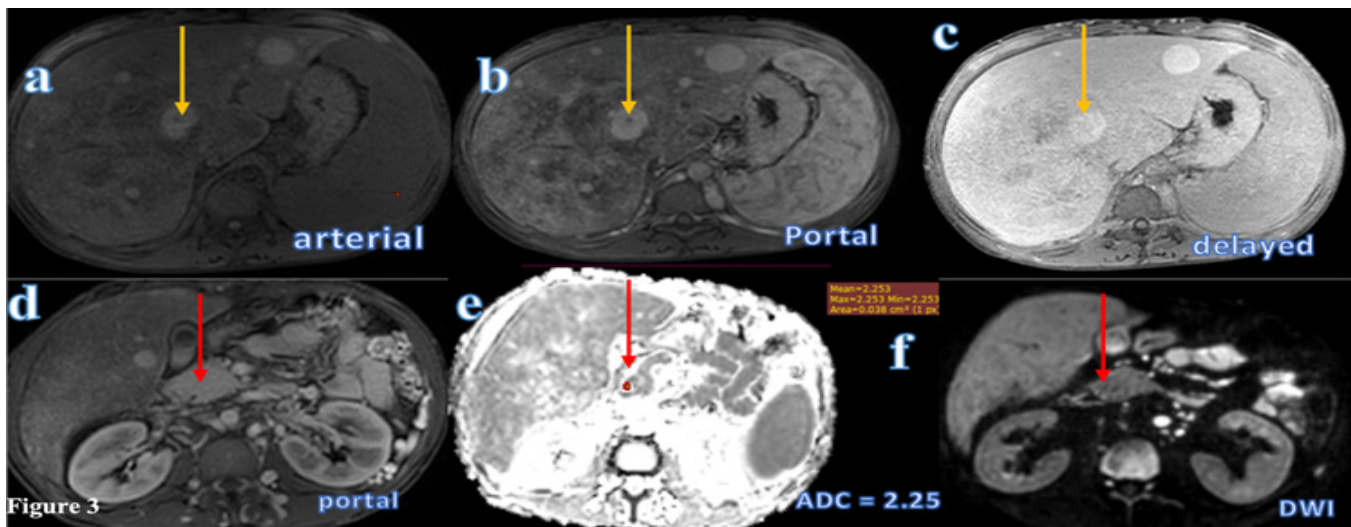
A 71 year-old cirrhotic patient. (a) Arterial, (b) porto-venous and (C) Delayed images show ill-defined heterogeneously enhancing lesion occupying most the right hepatic lobe segments and smaller segment VIII focal lesions with enhancement pattern keeping with HCC(yellow arrows). (d) Portal phase showing a mass is seen infiltrating the right main portal vein (red arrows). (e) ADC map showing PVT; ADC value =  $1.18 \times 10^{-3} \text{ mm}^2/\text{s}$  keeping with malignant PVT. (f) DWI showing restricted diffusion.
